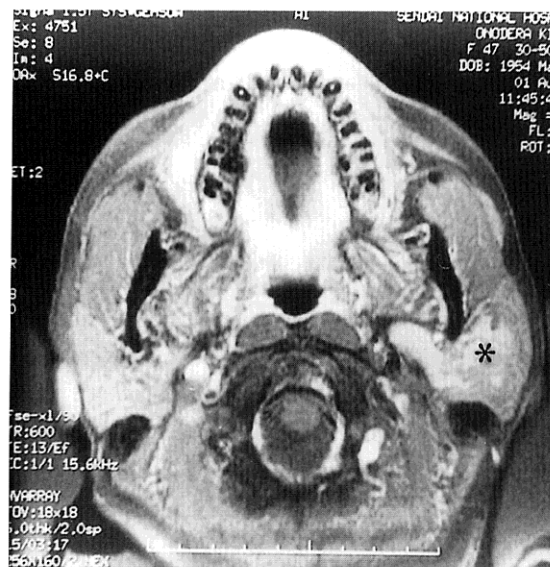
Gadolinium-enhanced T1-weighted magnetic resonance image (axial section).
